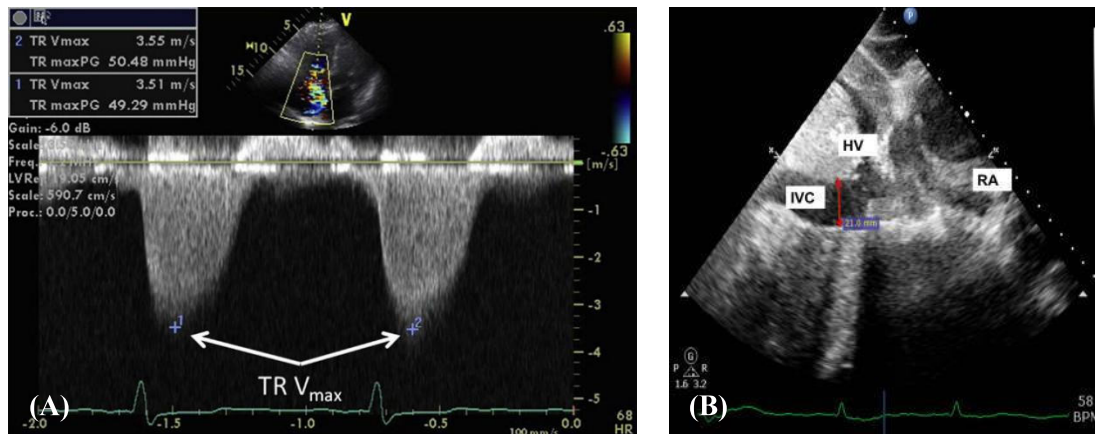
Estimation of the pulmonary artery systolic pressure (PASP) by using modified Bernoulli equation, $PASP \text{ (mmHG)} = 4(V_{\max} \text{ of the TR})^2 + RAP$. (A) The maximum velocity (V_{\max}) of TR is obtained from continuous-wave Doppler echo (François & Schiebler, 2016) (B) The right atrial pressure (RAP) is estimated from IVC collapsibility (or sniff) obtained in SIVC view. Abbreviations: Hepatic vein (HV); right atrium (RA) (Garijo et al., 2017)
